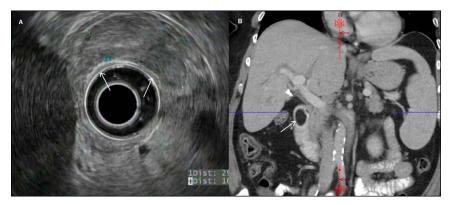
Endoscopic ultrasound showing (A) a large duodenal mass arising from the submucosa (arrows) and contrast-enhanced computed tomogram of the abdomen showing (B) a mass (arrow) at the duodenal bulb with homogeneous fat density.
